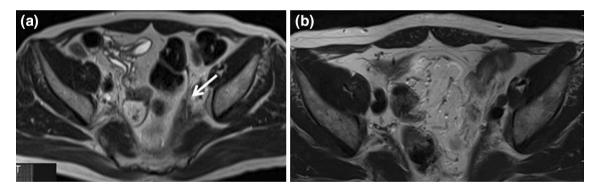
MRI performed 1 month after starting steroids shows reduction in size of the retroperitoneal mass (*arrow*) (a). The mass almost disappeared on MRI performed 10 months later (b)
